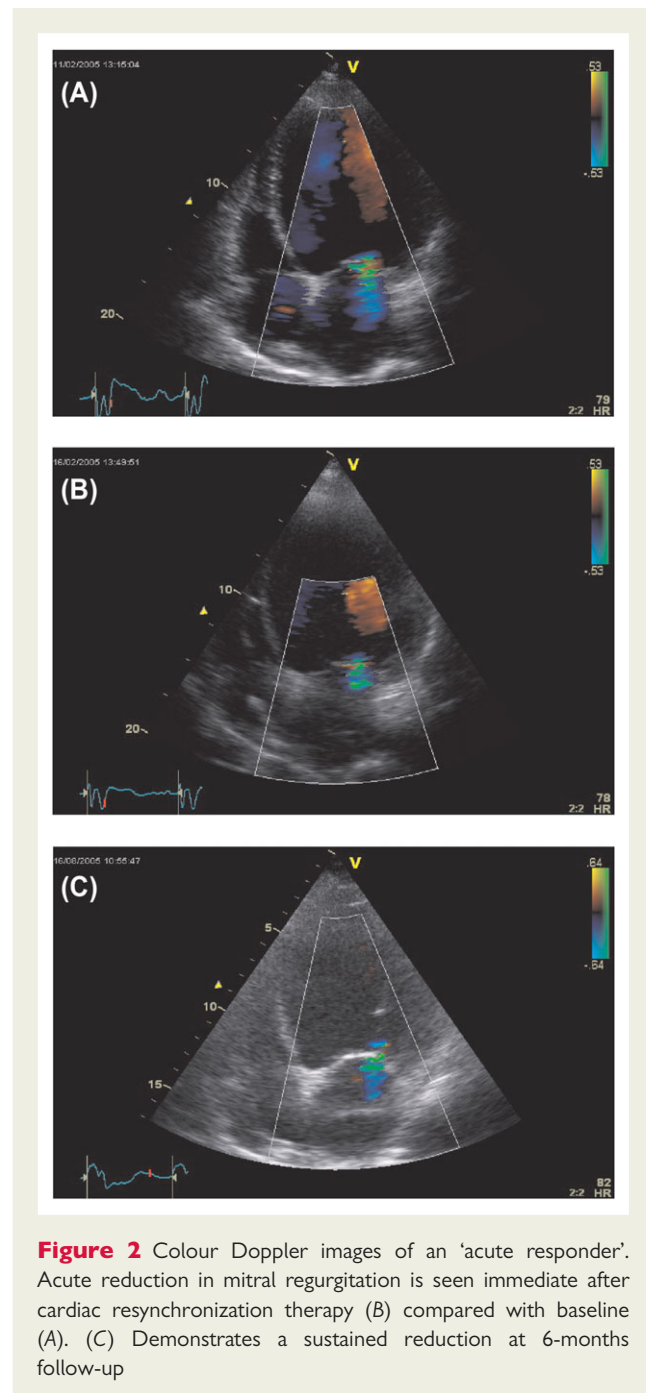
Colour Doppler images of an 'acute responder'. Acute reduction in mitral regurgitation is seen immediate after cardiac resynchronization therapy (B) compared with baseline (A). (C) Demonstrates a sustained reduction at 6-months follow-up
